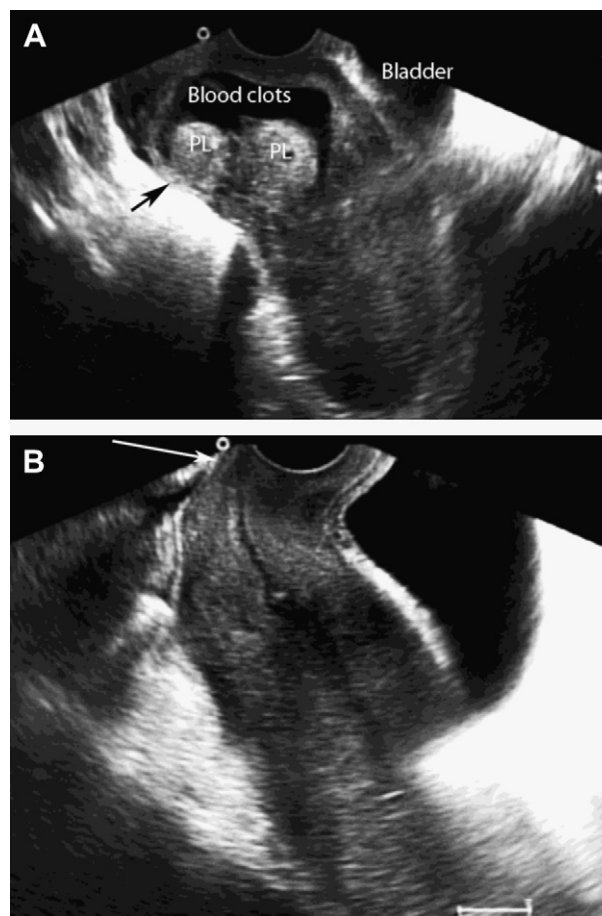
(A) Transvaginal sonography performed 10 days after vaginal delivery displayed blood clots and residual placental tissues (PL), which were adhered to the thin posterior uterine wall (arrow) and associated with significantly less vascularity compared to previous ultrasound appearance. The blood clots and the residual placenta were removed by the use of a ring forceps under ultrasound guidance. (B) The follow-up transvaginal sonography was ordinary except that there was a thin wall in the posterior lower segment of the uterus (arrow).
